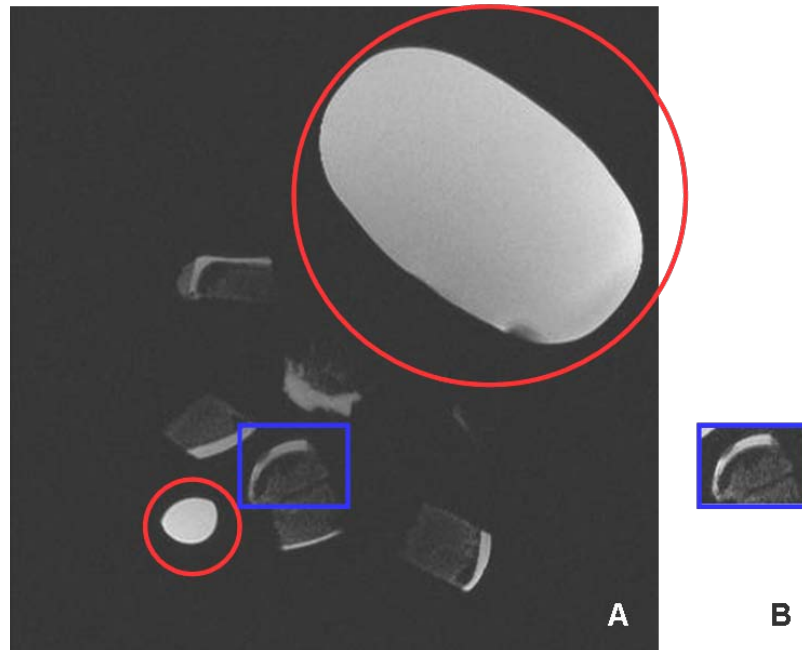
An MR image extracted from 3.0T MRI of cartilage samples. (A) Image showed multiple samples. The objects highlighted by red circle were 0.9% (w/v) sodium chloride solution which was used to enhance the MR signal. The blue square highlighted a femoral condyle. (B) The femoral condyle was segmented using Analyze™ for wear quantification.
